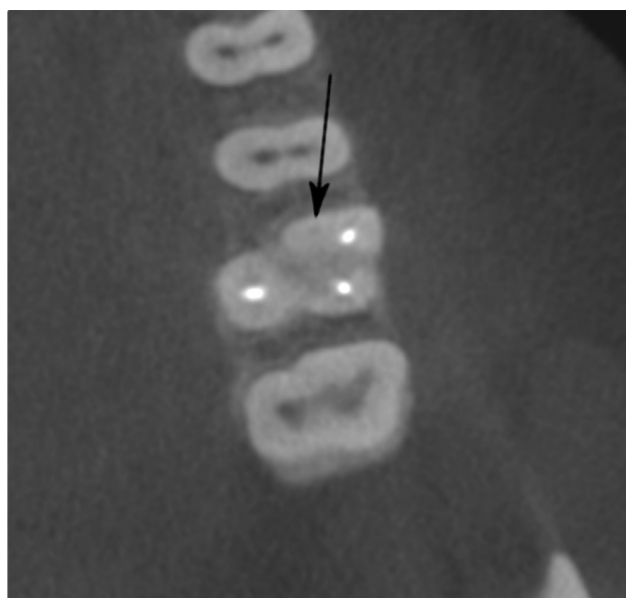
A CBCT axial scan of an upper molar with a missed second mesiobuccal canal.
